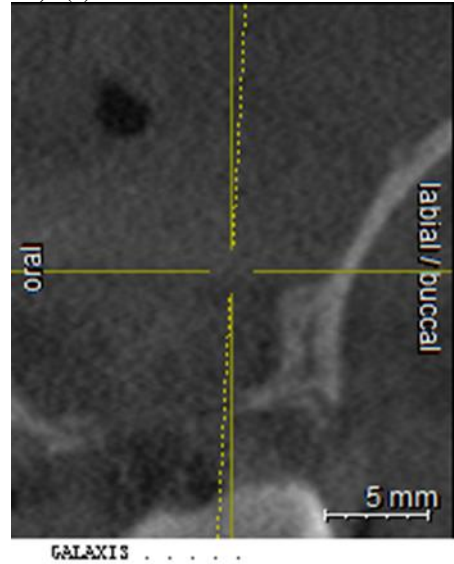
CBCT image showing cross sectional view at the interdental region of 14 and 15 with loss of continuity at the alveolar crest suggestive of perforation.
